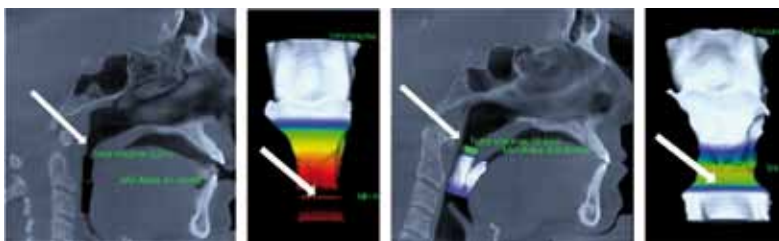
Increased volume of the respiratory tract (CBCT data) before (a, b) and after (c, d) combined orthodontic & surgical treatment
